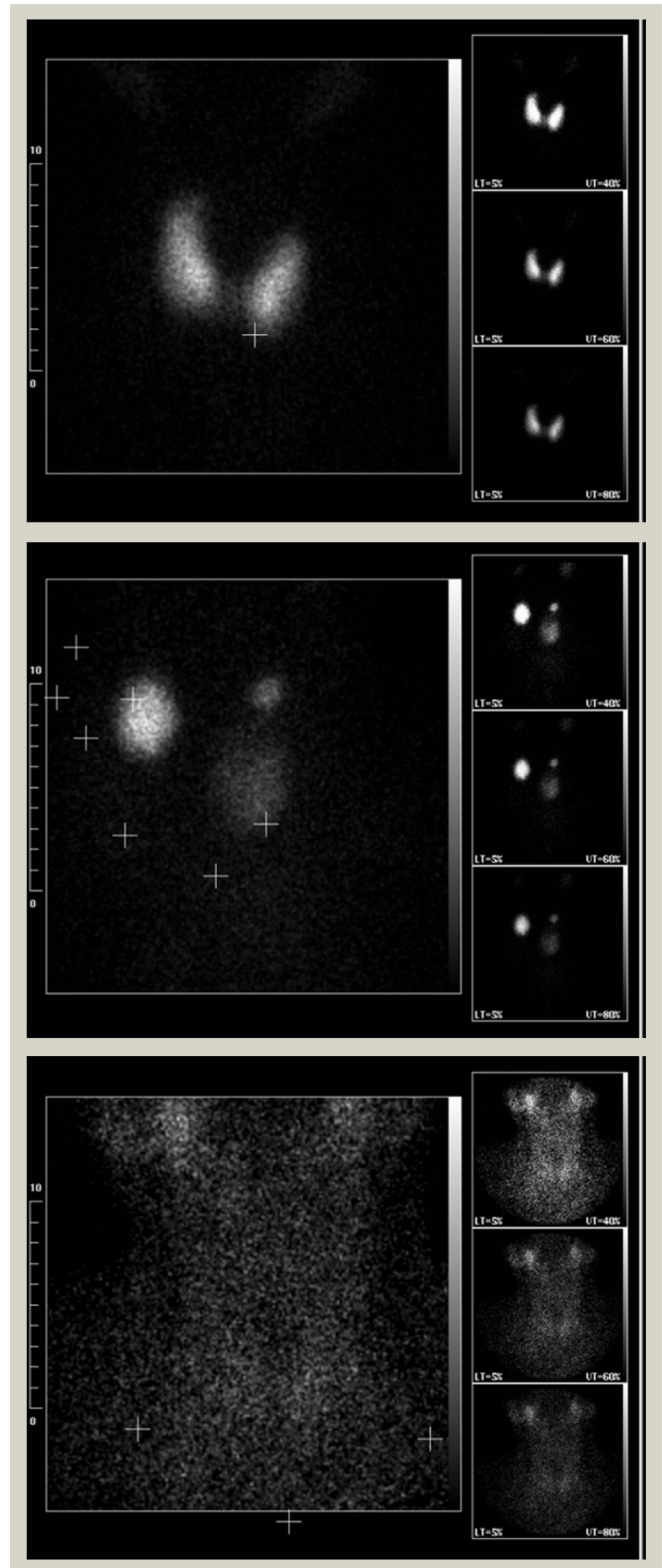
Thyroid scintigrams showing Graves' disease (top), toxic multinodular goitre (middle) and thyroiditis (bottom).
